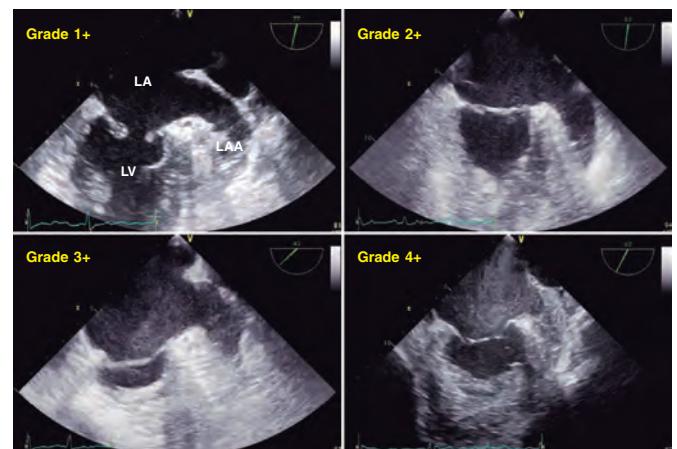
Two-dimensional transesophageal echocardiography image. A total of 4 different grades of spontaneous contrast can be seen in the atrium and the left atrial appendage going from lower to higher intensity (1+ to 4+). LA, left atrium; LAA, left atrial appendage; LV, left ventricle. Reproduced with permission from Ito and Suwa.³²
